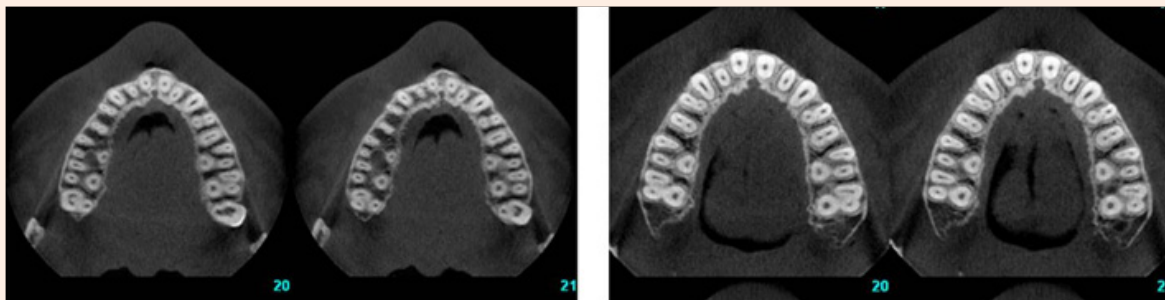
Cone Beam images before and after treatment.
